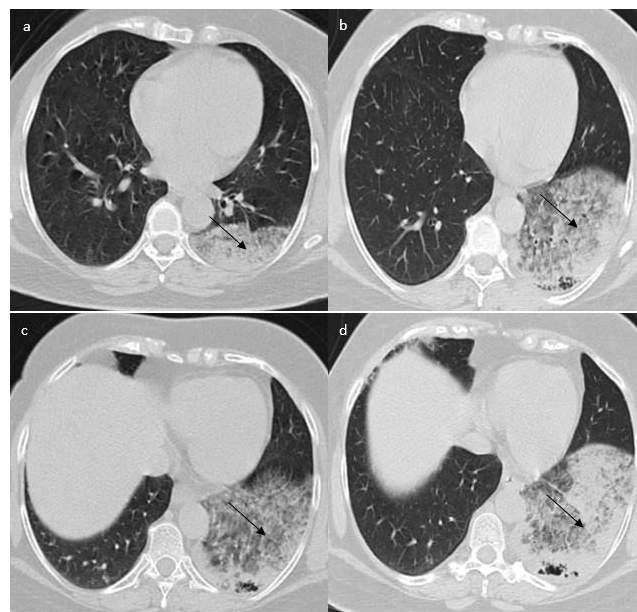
HRCT axial cut showing large airspace consolidation in the superior and basal segments of the left lower lobe with areas of breakdown. Interval increase in the size and density of the consolidation noted over a period of 2 months. (a) Large patchy consolidation in the left lower lobe, involving the superior segment (first consult), (b) Chest CT showing an increase in patchy consolidation and apical segments (at the time of hospitalization), (c) Large patchy consolidation in the left lower lobe involving the basal segments (first consult), (d) Increase in consolidation – basal segments (at the time of hospitalization)
